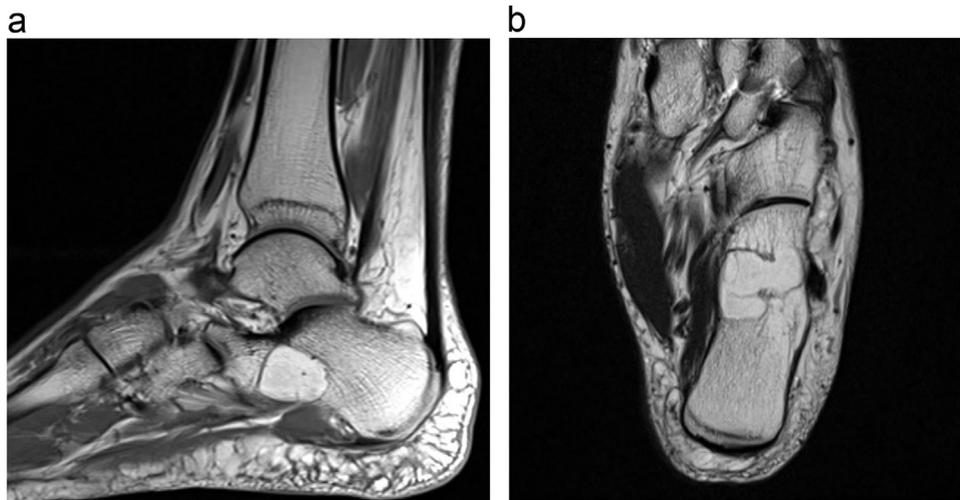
a & 2b A MRI scan shows a well defined ovoid lesion with uniform high signal intensity on T1-weighted image, in the neck of calcaneus.
